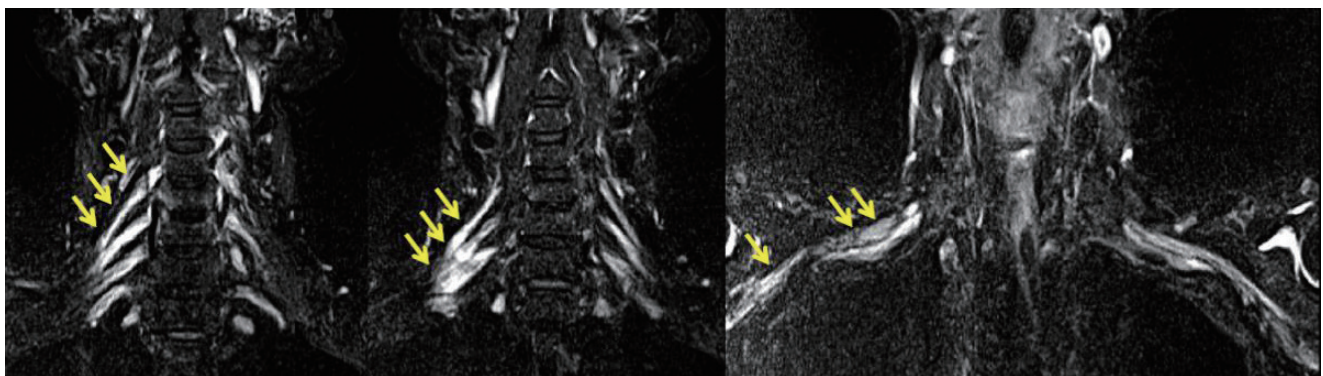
Brachial plexus magnetic resonance imaging (Short T1 Inversion Recovery Image, non-contrast enhanced) revealed fusiform hypertrophy of the right C5-C8 roots, and plexus was observed (arrows). No hypertrophy was observed on the left side.
